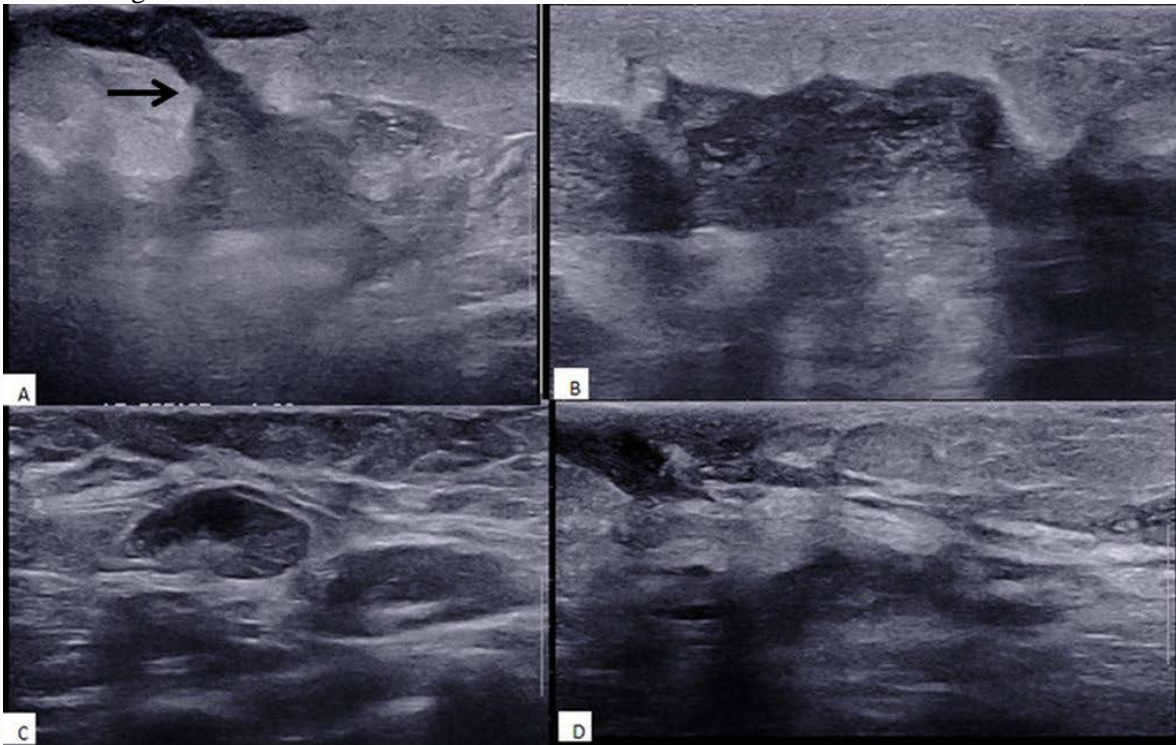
A 33-year-old patient, presented with pain in the right breast. A to C: Ultrasound revealed multiple dilated ducts with mobile internal echoes, thickened walls traceable up to the nipple and increased periductal vascularity. The surrounding parenchyma shows inflammatory changes. D: Right axilla shows enlarged lymph nodes with diffuse cortical thickening. Biopsy was suggestive of granulomatous lobular mastitis.
